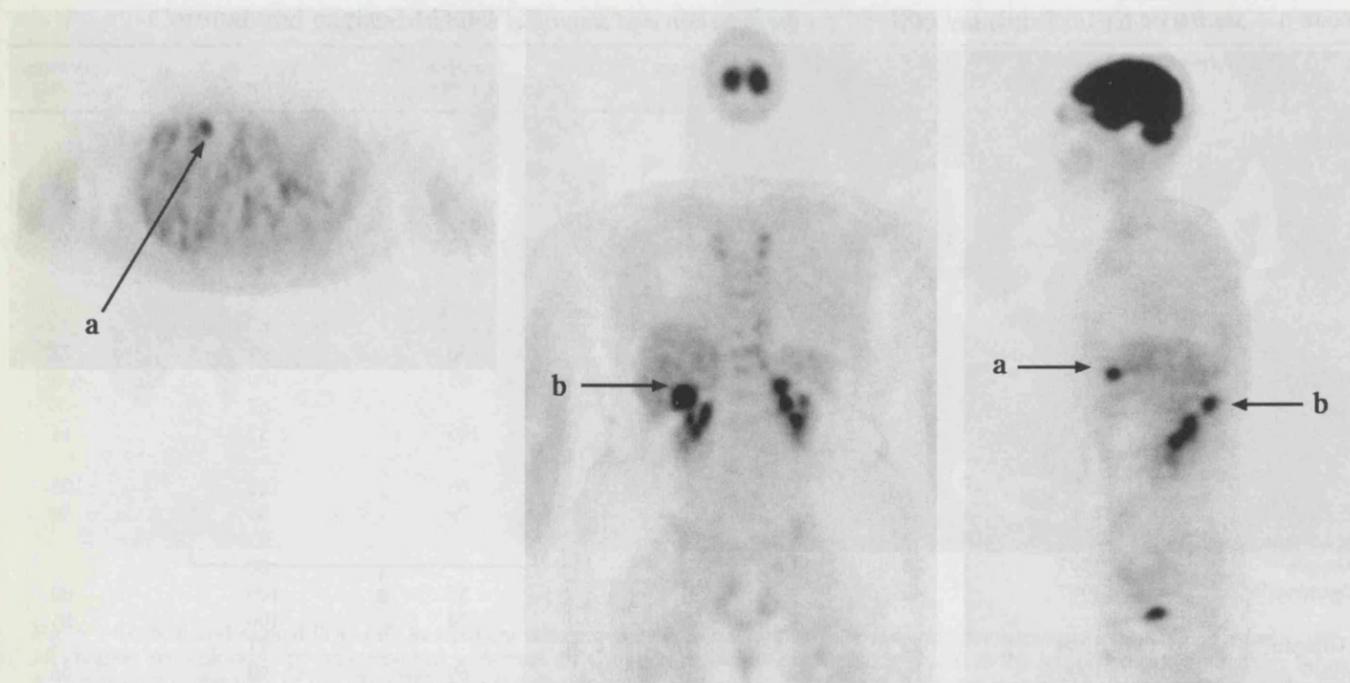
A-C) FDG-PET study in a patient who was diagnosed on CT as having a solitary colorectal liver metastasis that was deemed operable. This study, however, demonstrates two liver lesions (a) and (b).
